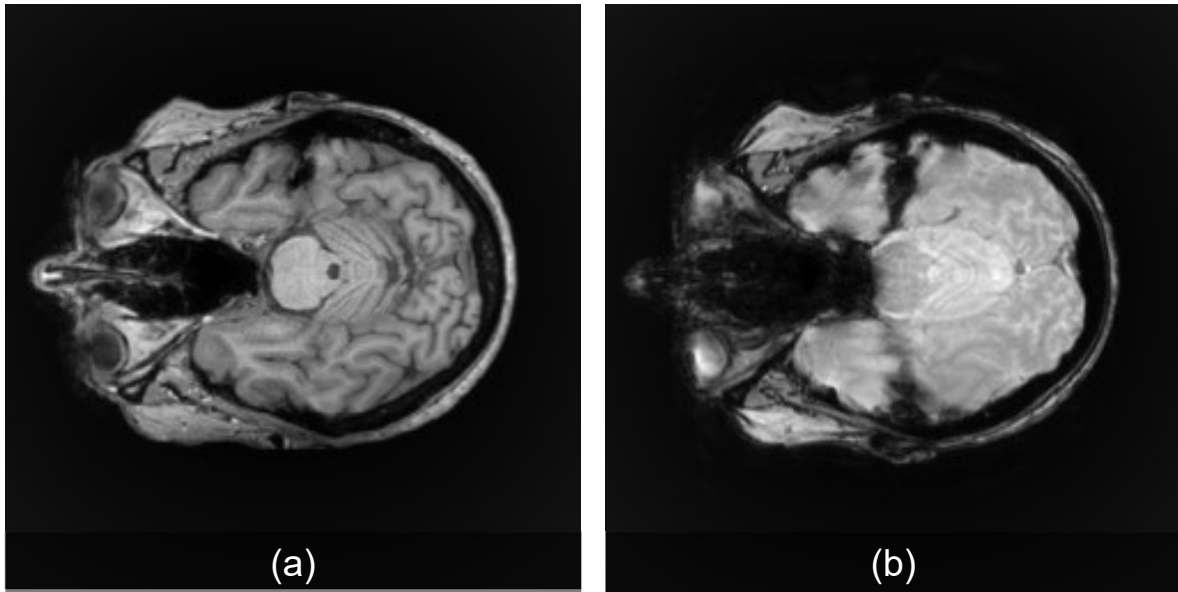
(a) T1-w MR image, (b) T2-w MR image.
